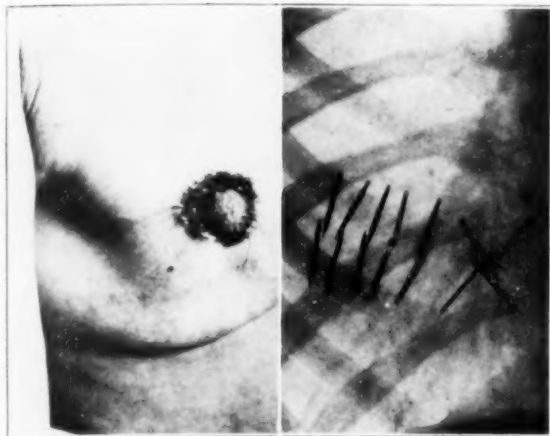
Paget's disease, with deep involvement. There was a mass to the right of the nipple, about three by two inches. One hundred and forty milligrams, in fourteen needles, were imbedded, as shown in the radiograph, and left in place for five hours. This was followed the same day by heavy x-ray treatments over the breast and glands draining it. Completely healed. Later there was a slight recurrence, which is being treated by x-ray, at the present time.
